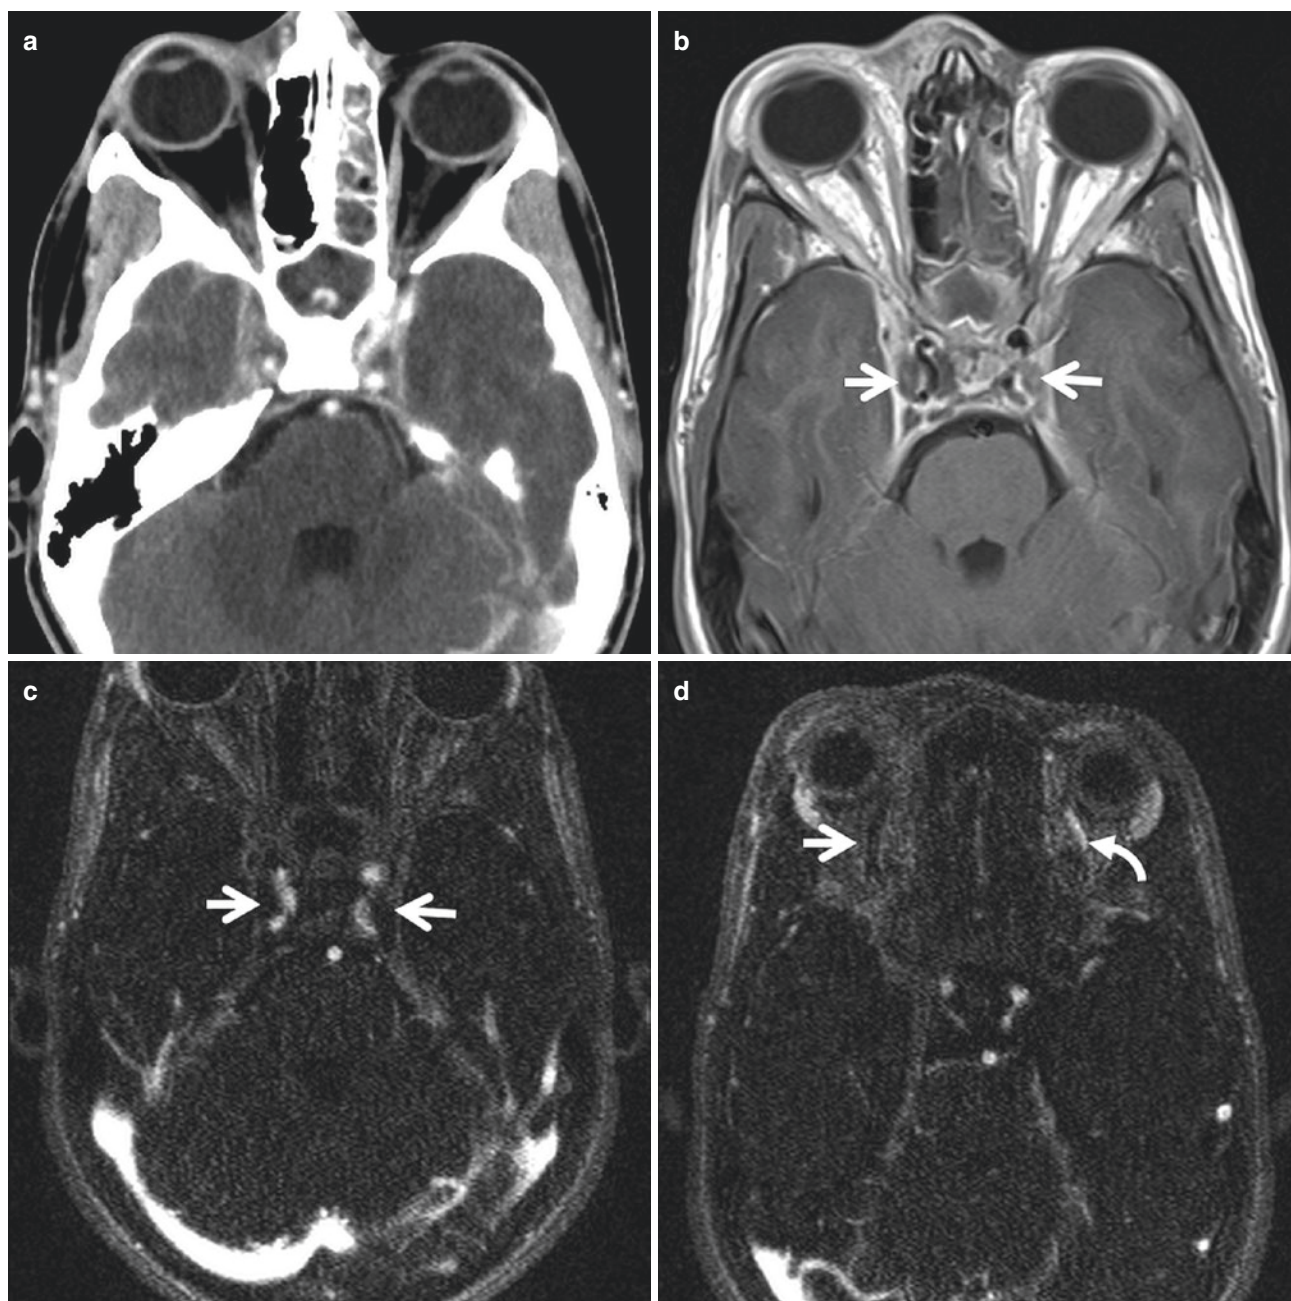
Cavernous sinus and superior ophthalmic vein (SOV) thrombosis due to sinusitis. Child with leukemia on chemotherapy presents with headache and right eye swelling. (a) Postcontrast CT demonstrates fluid opacification of sphenoid sinuses and left ethmoid air cells consistent with acute sinusitis. The bilateral cavernous sinuses are expanded and non-enhancing, suggestive of thrombosis. (b) Postcontrast T1 MRI
